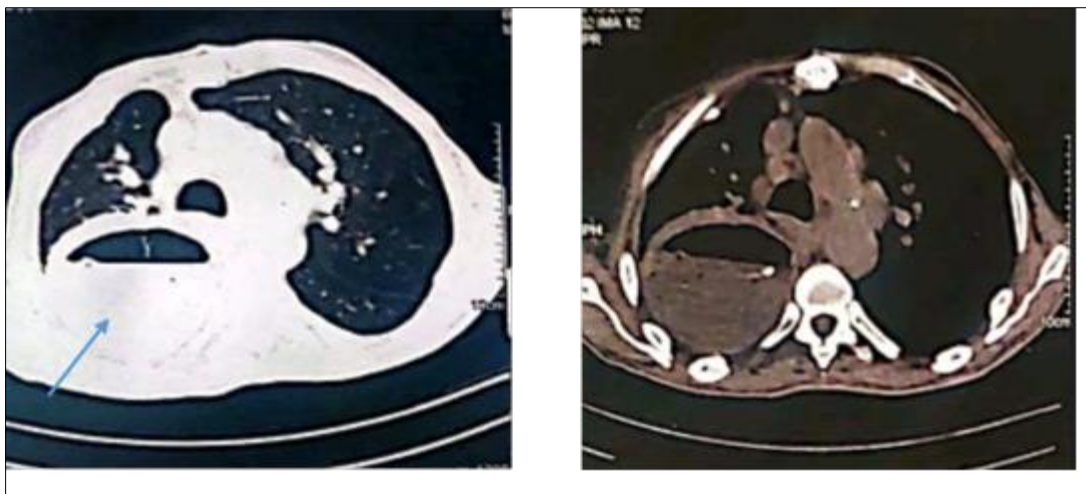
The thoracic computed tomography (CT) scan performed during hospitalization accurately characterized the pulmonary abscess in the right lower lobe. The examination revealed a well-defined hydro-aerial collection measuring approximately 8 cm in diameter, with regular contours. This presentation is typical of a pulmonary abscess, indicating an accumulation of pus within the pulmonary parenchyma
